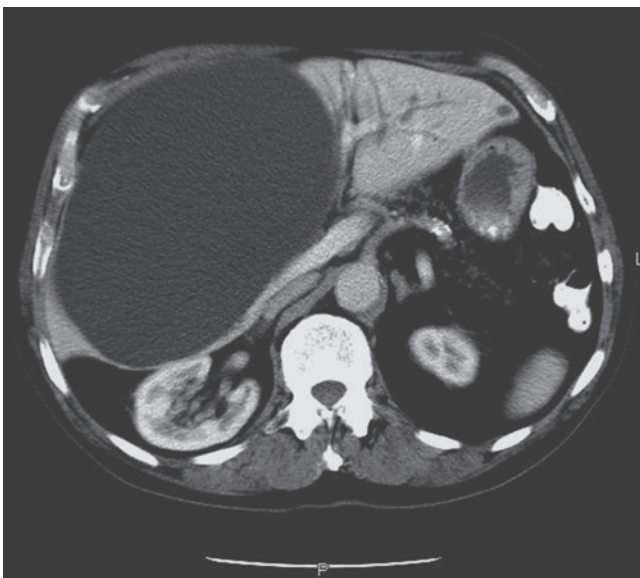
CT demonstrating a large simple cyst compressing the hepatic veins and inferior vena cava and abutting the left portal venous system.
